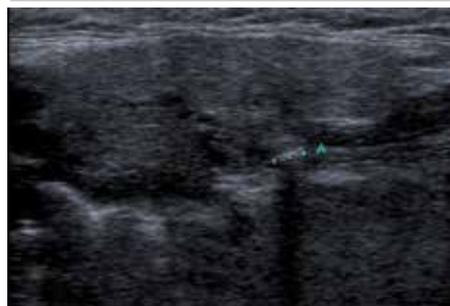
Ultrasound of submandibular gland, stone identified (A).
